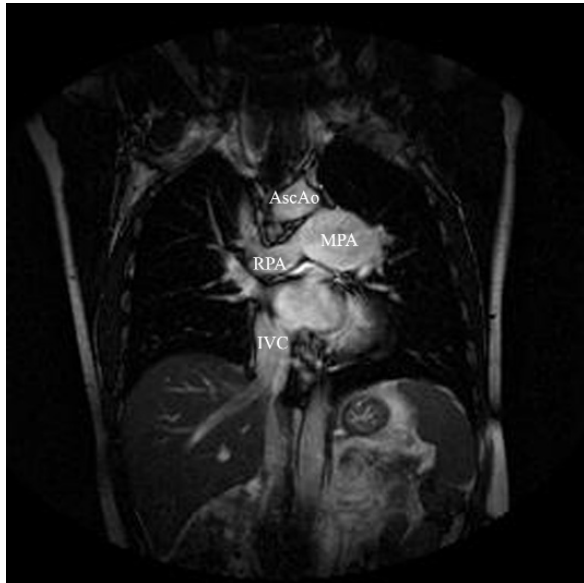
Preoperative thorax magnetic resonance imaging showing the pulmonary artery aneurysm in the first patient. AscAo indicates ascending aorta; MPA, main pulmonary artery; RPA, right pulmonary artery; IVC, inferior vena cava.
